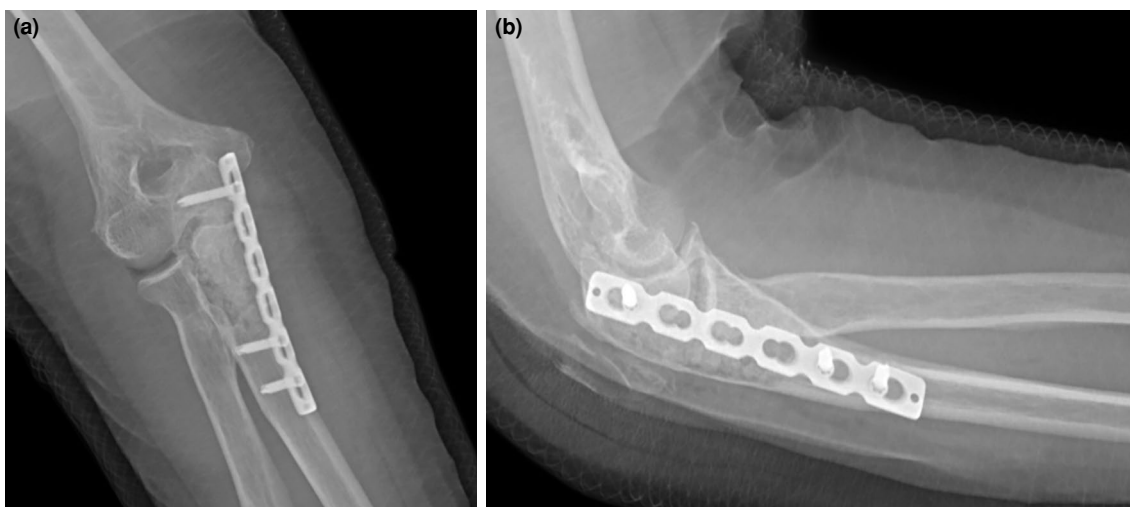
Postoperative X-ray appearance. (a) Anteroposterior X-ray (b) Lateral X-ray.
